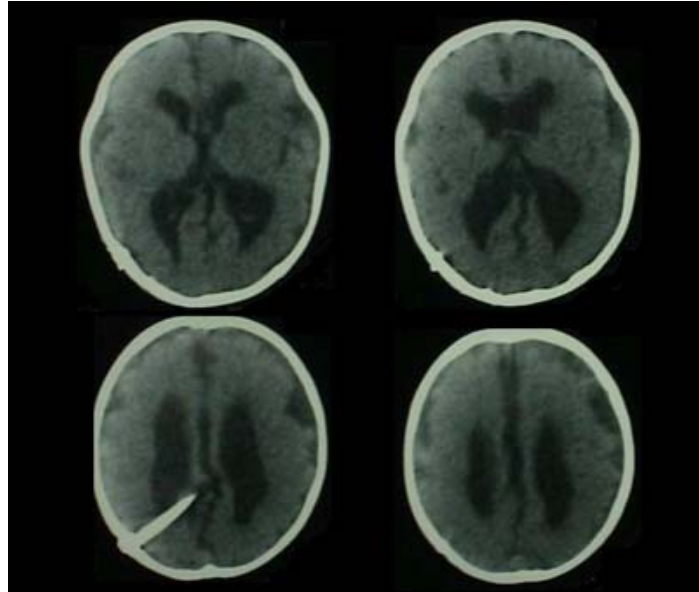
Postoperative brain CT scan demonstrating decrease in size of ventricles.
